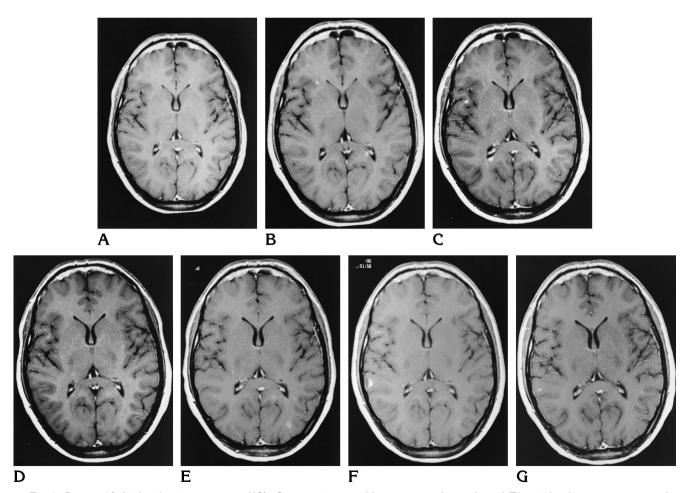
Patient 10 (with relapsing-remitting MS). Consecutive monthly contrast-enhanced axial T1-weighted images covering the entire follow-up period. Several enhancing lesions are visible in different brain regions on five of the seven images.
